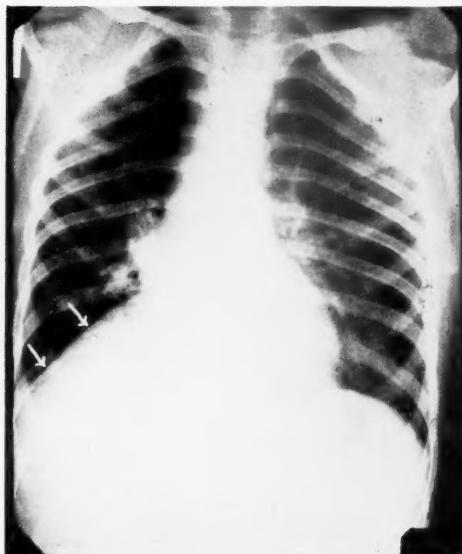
Radiograph of a nine-year-old boy with an atelectatic triangular shadow at the base of the right lung, present many years. History of repeated attacks of "pneumonia."
